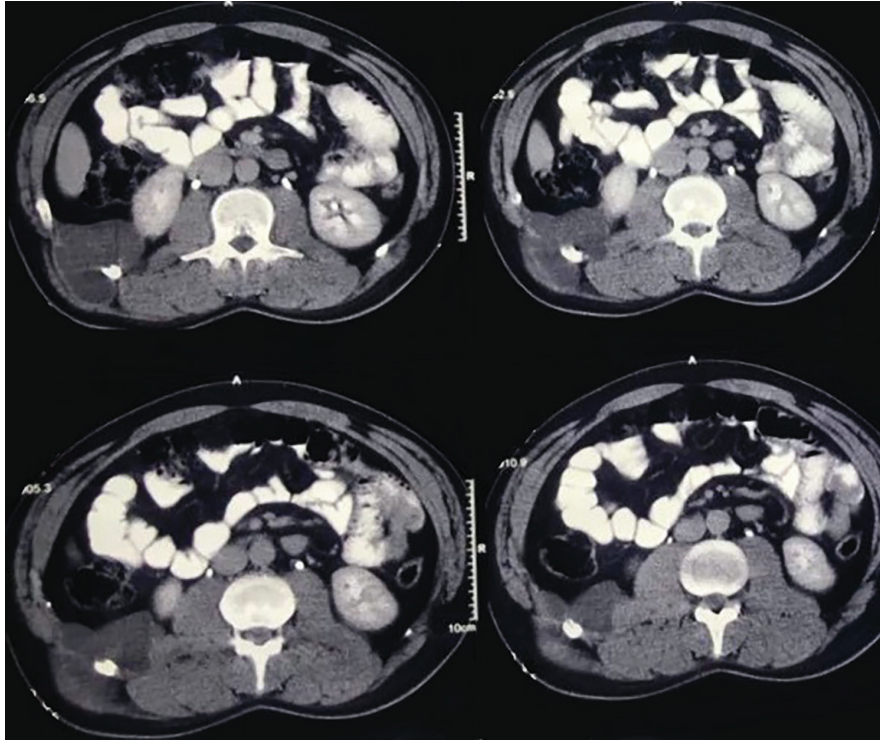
Contrast-enhanced computed tomography (CT) scan showed a large cystic mass between the eleventh and twelfth ribs with extension to the posterior abdominal wall.
